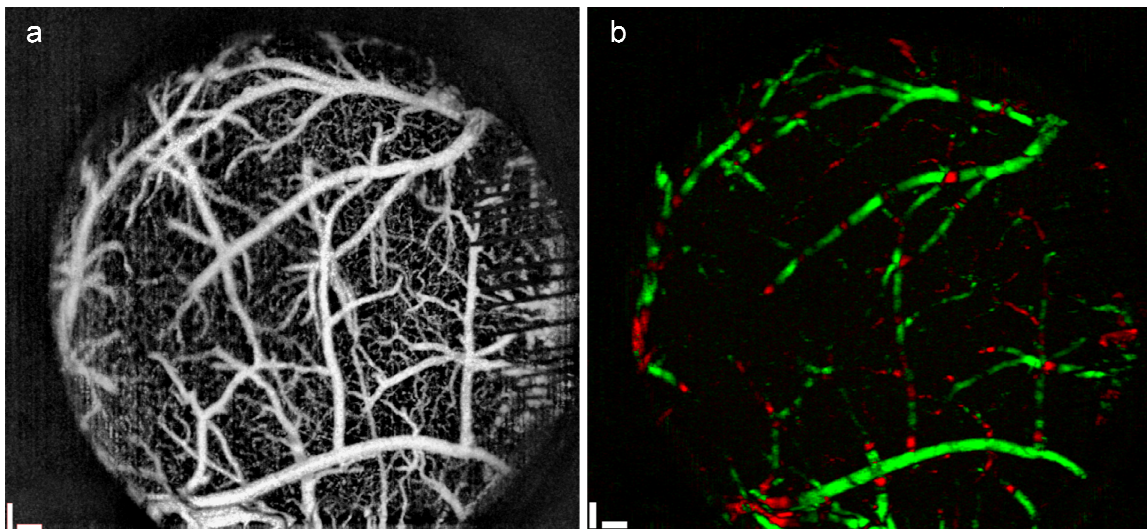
Optical coherence tomography through CLEAR device. (a) OCT angiogram showing cortical vasculature visible through CLEAR micro-ECoG device. (b) Doppler blood flow velocity image showing the directionality of blood flowing through the vasculature below the device. Green represents blood flowing towards the camera, and red represents blood flowing away.
